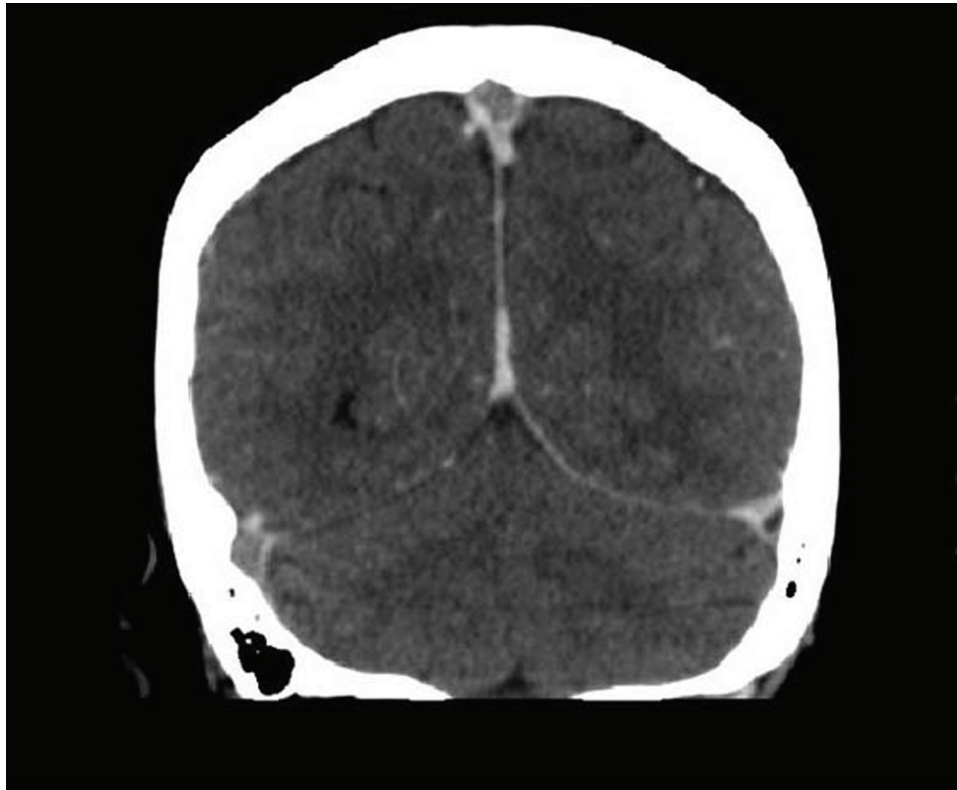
Coronal segment CT venogram.
